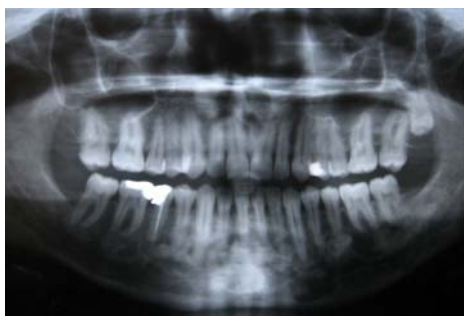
Panoramic radiograph taken 1 year after the last visit, demonstrating no changes compared with 2007
